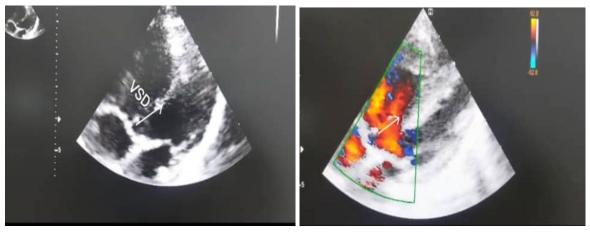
Echocardiographic image of VSD before closure
